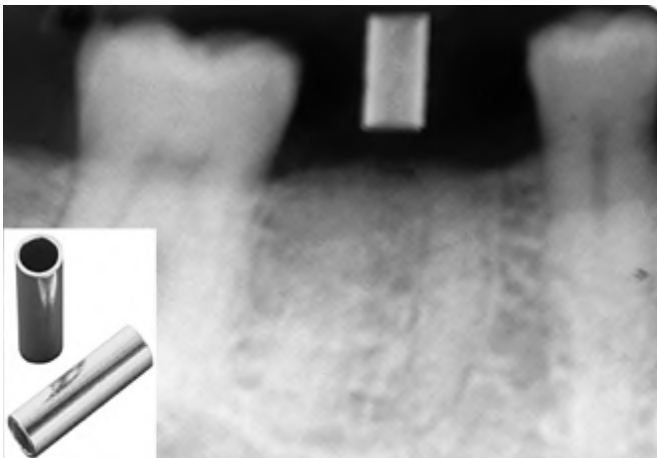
Preoperative radiograph with the surgical guide in place. The periodontist placed a stent guide tube (SGT25) into the surgical guide. The guide tube was designed for use with 2-mm twist drill (lower left corner inset).
